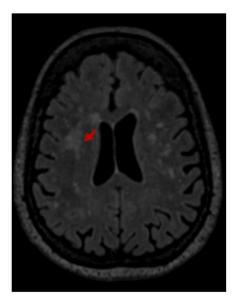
T2-weighted brain MRI from participating patient showing semiovale centrum confluent white matter hyperintensities (WMH).
